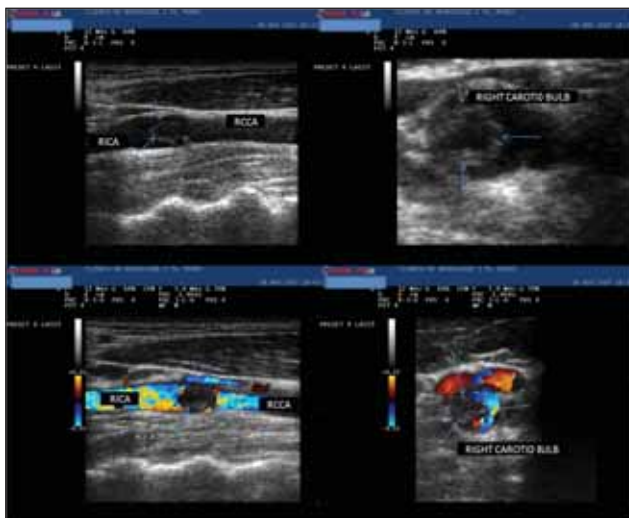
Carotid duplex ultrasonography. Mobile thrombus in the right carotid bulb.
